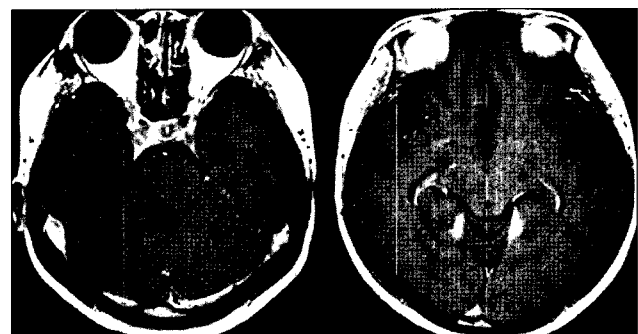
One month later, enhanced T1-weighted magnetic resonance images after Gamma-Knife radiosurgery showing markedly decreased tumors size.
